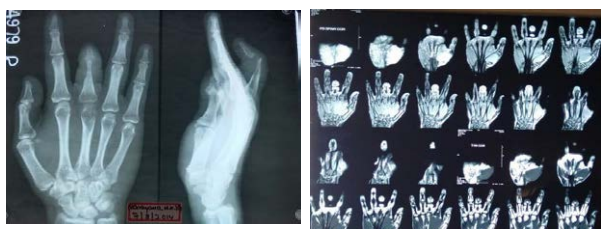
Pre-operative X-ray and MRI results.
